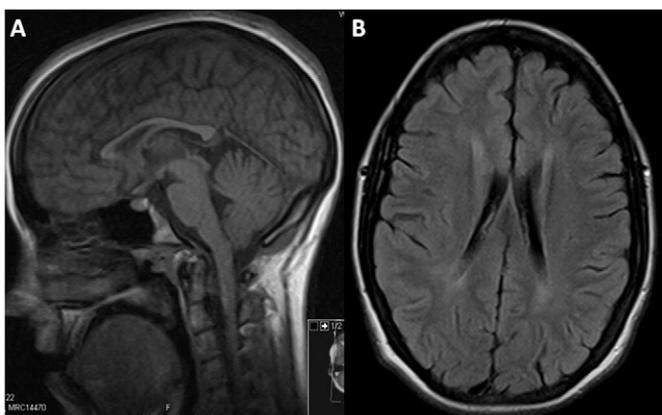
Brain MRI study of the patient. (A) Sagittal T1WI revealed a thin corpus callosum; (B) axial FLAIR showed slight hyperintense lesions affecting the periventricular white matter.
